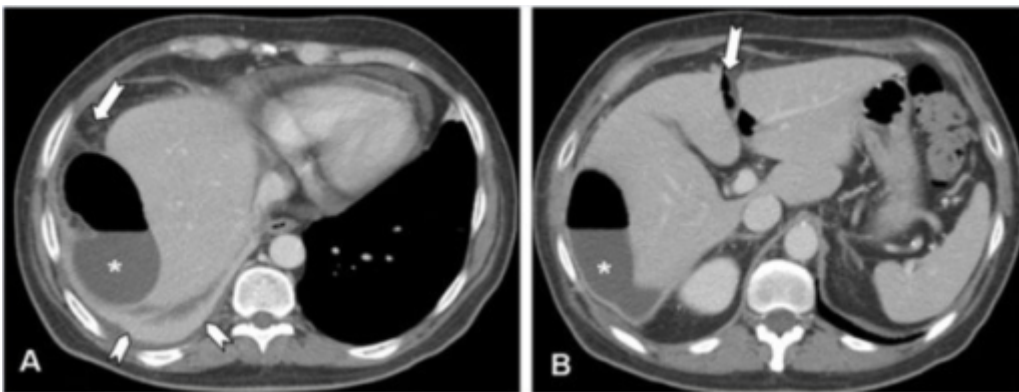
"Multi-detector contrast-enhanced computed tomography. Axial scans at the level of the upper abdomen are shown. In (A), a huge air-fluid collection (asterisk) can be seen in the right subphrenic space with mild stranding of the surrounding fat (arrow). There are also reactive pericardial and pleural effusions, the latter with associated atelectasia of the right lung base (arrowheads). In (B), the air-fluid collection (asterisk) appears to extend to the perihepatic space. Extraluminal air bubbles can also be detected in the fissure of Teres' ligament (arrow)" by Camera L, Calabrese M, Romeo V, Scordino F, Mainenti PP, Clemente M, Rapicano G, Salvatore M. License: [CC BY 2.0](https://creativecommons.org/licenses/by/2.0/)
